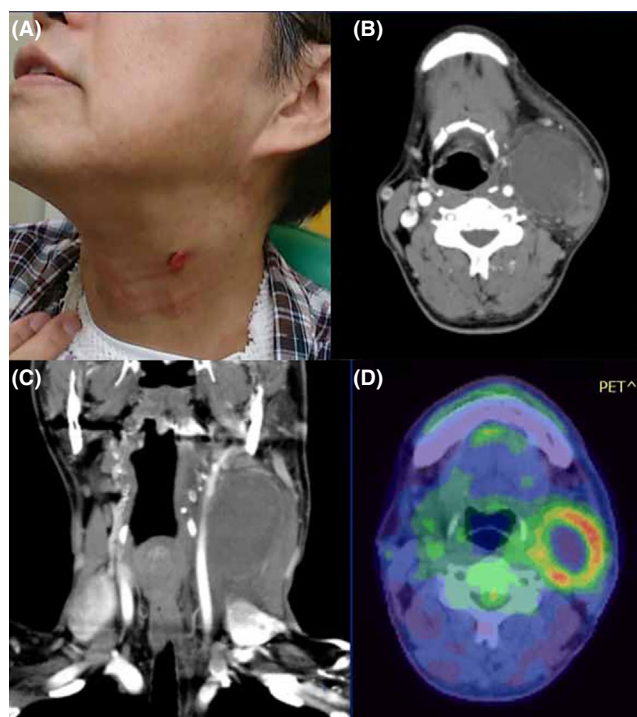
A, Ulcerated neck mass was seen. B, C, CT scan showed low-density mass with slight ring enhancement. D, PET scan showed the ring-like accumulation with no other abnormal lesions
